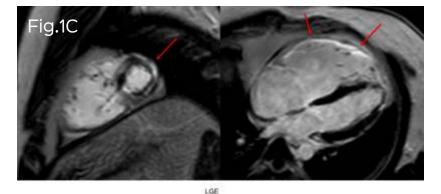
(A-D). Biventricular, RV predominant, arrhythmogenic cardiomyopathy. 40-years old with arrhythmias. Cardiac MRI shows abnormal wall motion in the axial and four-chamber (A) cines and the short axis (B) cines with areas of dyskinesia and pseudobulging (arrows). The late gadolinium enhanced (LGE) images (C) show areas of enhancement involving the RV free wall and the LV apex. The T1 image from a MOLLI sequence (D) shows fat in the RV myocardium.
